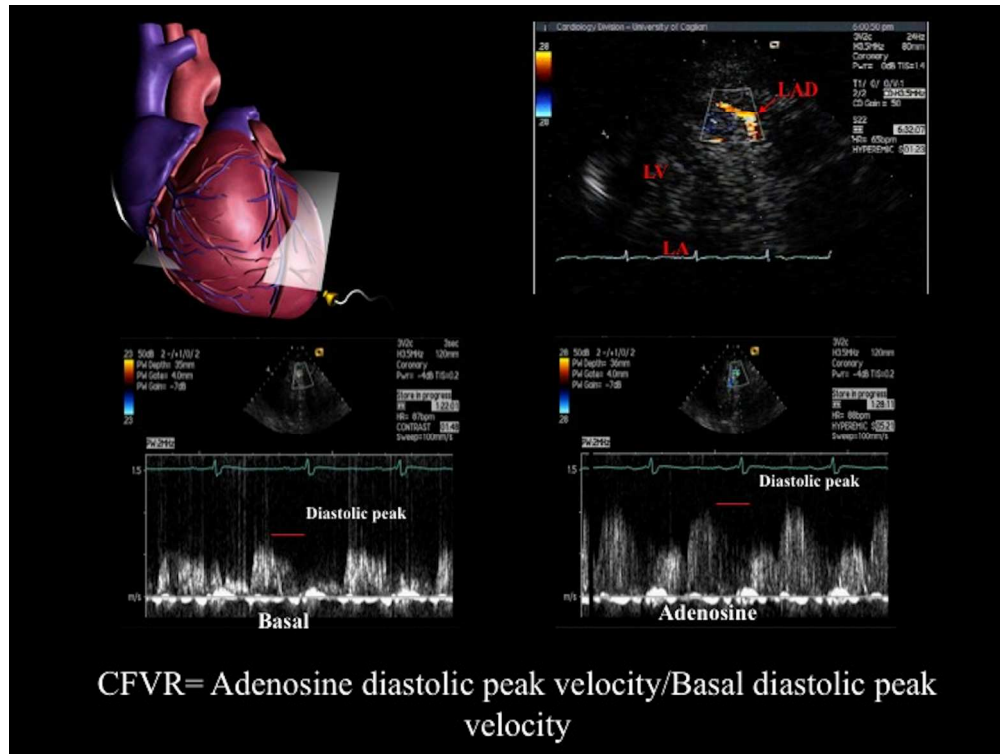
Tomographic plane orientation to left anterior descending coronary artery (LAD, top left) and color Doppler flow mapping in distal LAD in modified two chamber view in women with normal CFVR ( top right ) . Spectral Doppler tracing by sampling in distal LAD before (bottom left) and after adenosine infusion (bottom right). Coronary flow velocity reserve is calculated as adenosine diastolic peak velocity/basal diastolic peak velocity. LV= left ventricle; LA :left atrium; LAD: left descending artery
